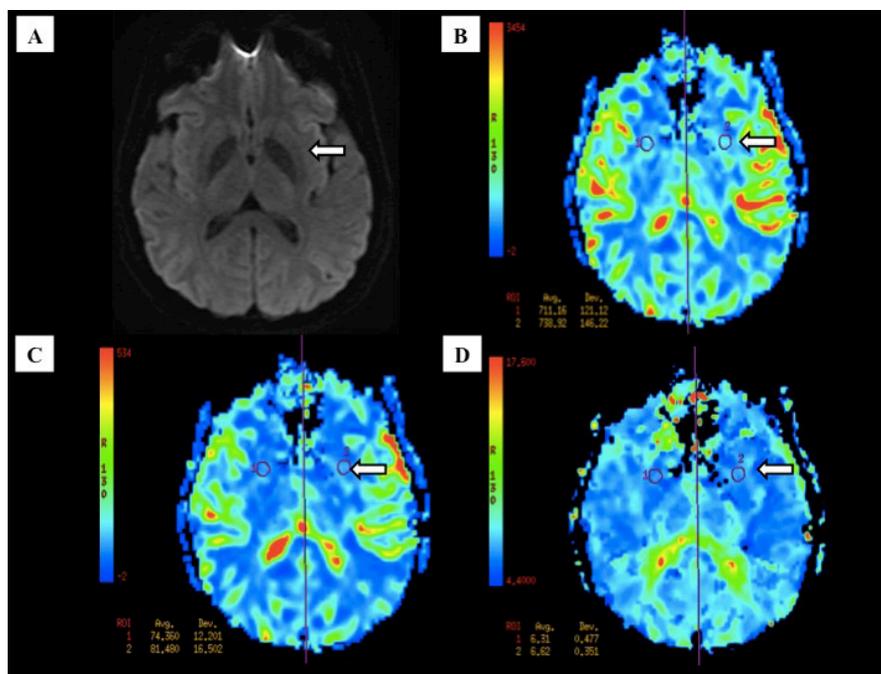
Perfusion maps in the age matched control subject. ROI is placed at the basal ganglia (white arrows) to derive the relative perfusion values. Axial MRI image in DWI of a normal patient (A). Brain perfusion is represented as 3 color-coded maps that consist of CBF (B), CBV (C) and MTT (D), which shows symmetrical perfusion in both brain hemispheres. Blue colour, which is the bottom of colour scale, indicates lowest perfusion value. Red colour, which is in the top scale of colour scale, indicates highest perfusion value.
